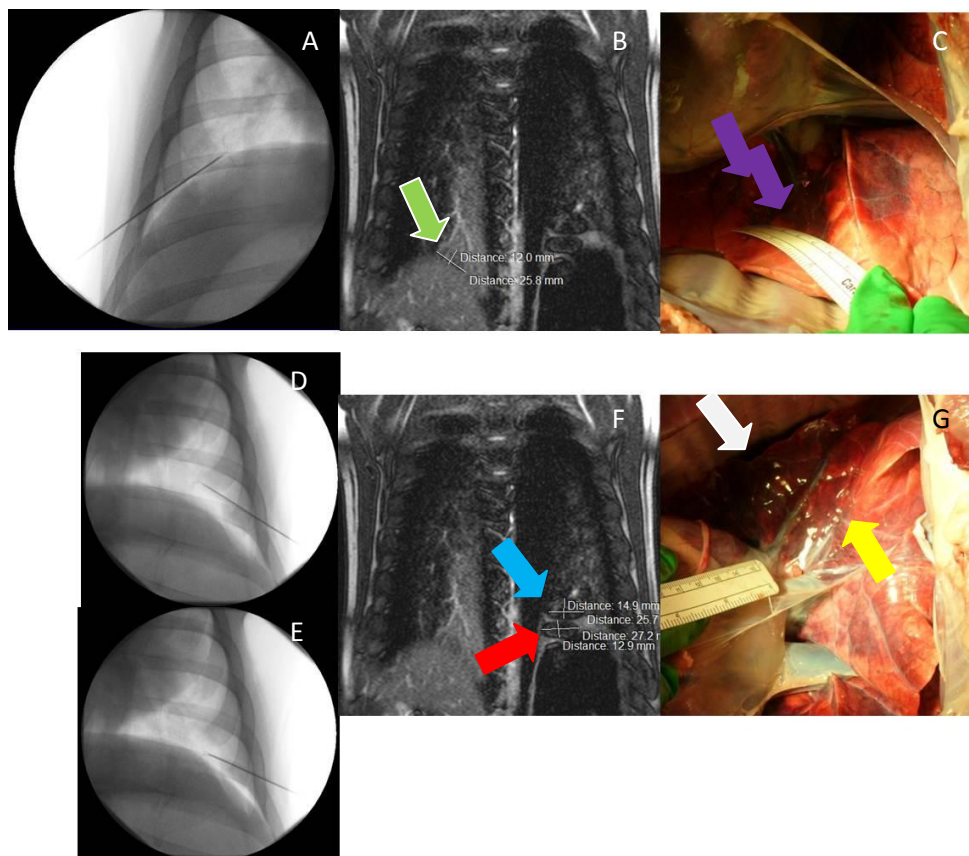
A: MR Needle placement in the right side (Fluoroscopy image); B: Post-ablation MRI (True FISP), showing the ablated area in the right side (green arrow); D: Necropsy image showing the ablated area in the right side (purple arrow). E: Needle placement in the left side in the 1st and 2nd positioning of the probe (Fluoroscopy image); F: Post-ablation MRI (True FISP), showing the ablated areas in the left side (red and blue arrows); G: Necropsy image showing the ablated areas in the left side (yellow and white arrow).
